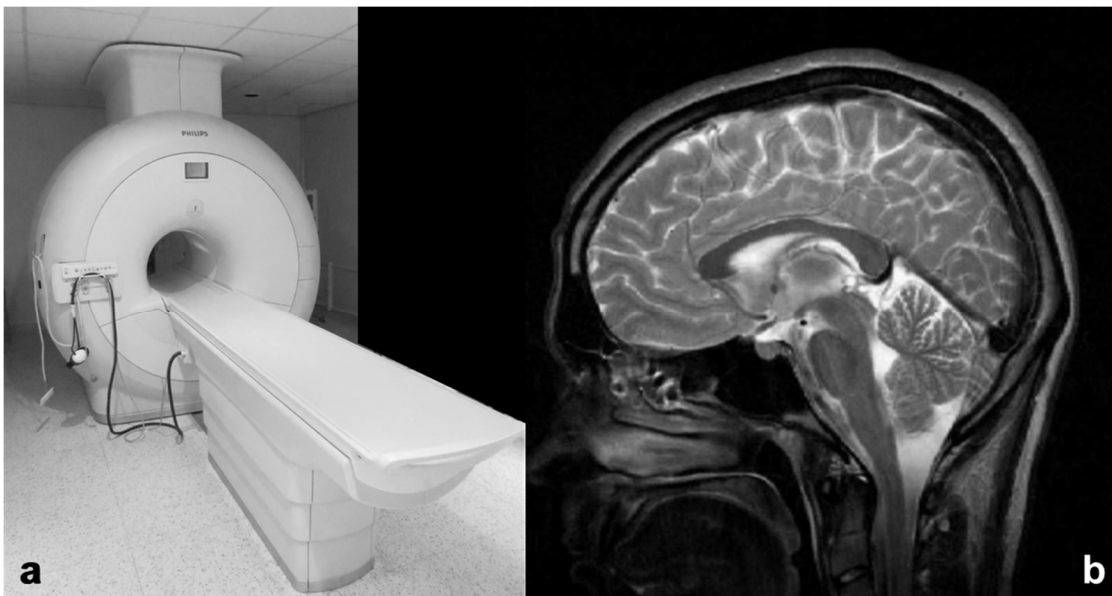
Example MRI scanner (a) and example MR image (b).
